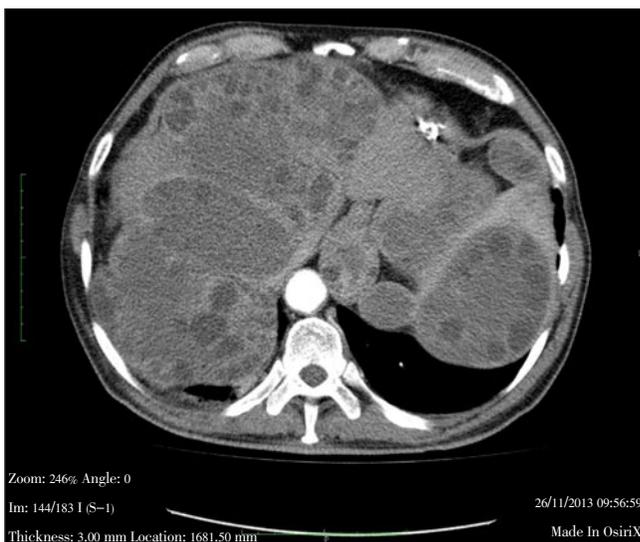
Axial contrast enhanced CT of the upper abdomen.
